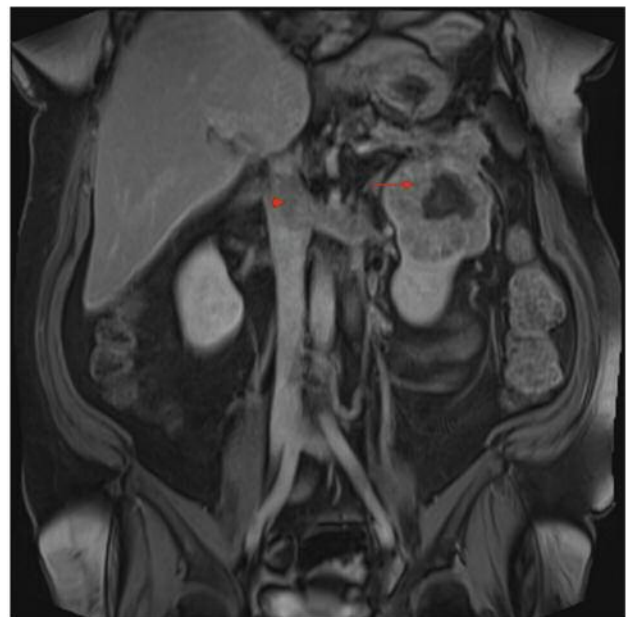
Abdominal MRI with left tumoral mass in upper pole (arrow) with renal vein and IVC tumoral thrombus (arrowhead).
